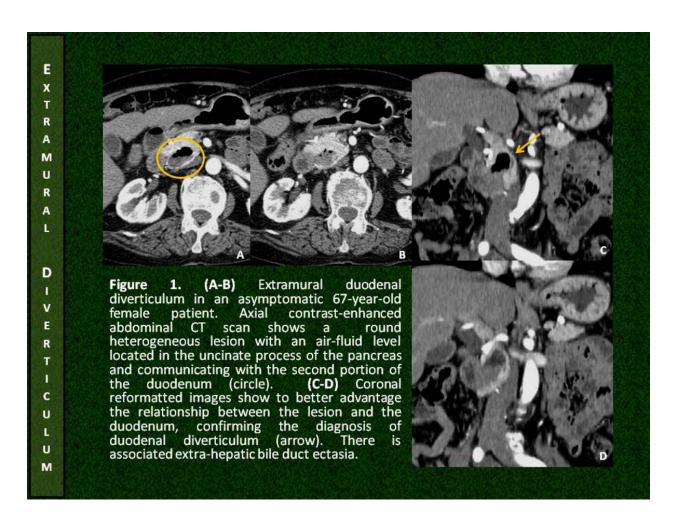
Extramural Diverticulum - CT References: C. Ruivo; Coimbra, PORTUGAL
